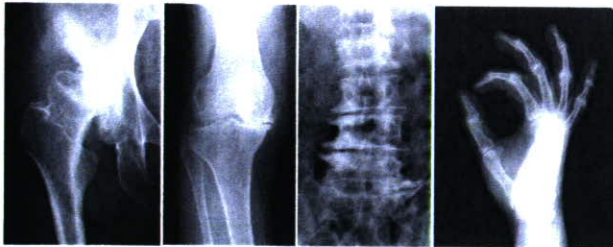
Radiographs of osteoarthritis (OA) in hip, knee, lumbar spine, and hand. Cartilage degradation shown as joint space narrowing and osteophyte formation at the edge of the joints are two major disorders of OA.
